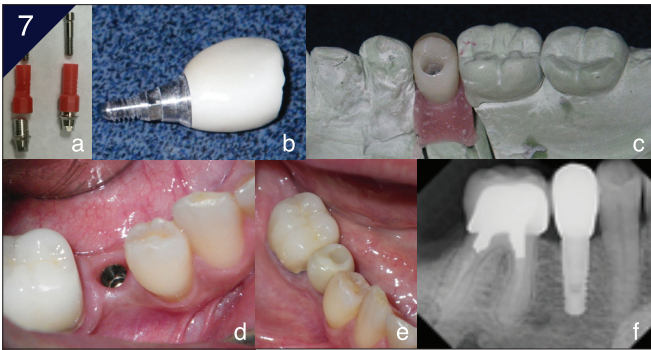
Screw Retained–Cemented Implant Crown (SR-CIC) protocol. a) Ti-base of DENTIS™ UCLA abutment was used after heat removing the red plastic sleeve and was placed over the lab analogue. b,c) A zirconia crown veneered with e-max ceramic was fabricated over Ti-base. Then, it was cemented with resin cement. d) Intraoral photo of the DENTIS™ S-Clean implant. e) The hybrid implant crown in the mouth. f) Radiograph of the implant crown on implant of the mandibular right second premolar.
